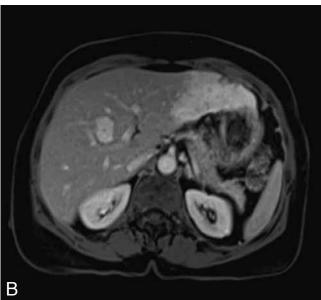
MRI of the liver with a (arterial -15 sec) and b delayed (2 min) phases depicts early peripheral nodular enhancement of two Hemangioma with delayed centripetal filling in.
